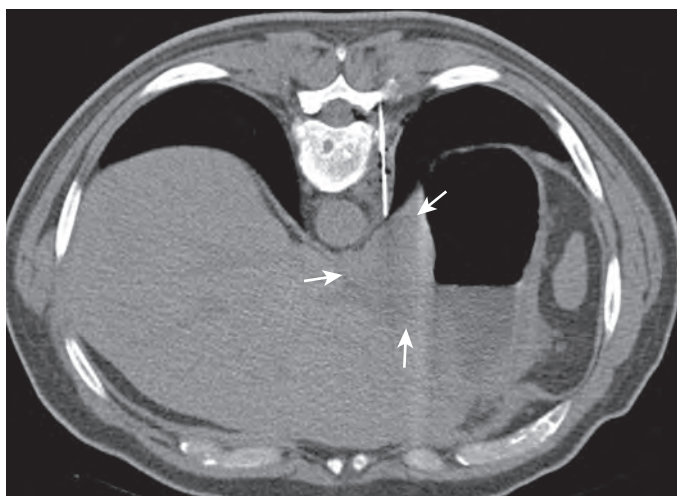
CT of a 55-year-old man with confluent adenopathy along the lesser curvature of the stomach (arrows). An 18-gauge Hawkins-Akins needle was advanced into the left paravertebral space, and approximately 30 mL of sterile 0.9% saline was injected to create an artificial space to avoid pulmonary transgression. Fine-needle aspiration biopsy revealed diffuse large B-cell lymphoma. A chest radiograph after the procedure demonstrated no pneumothorax.
